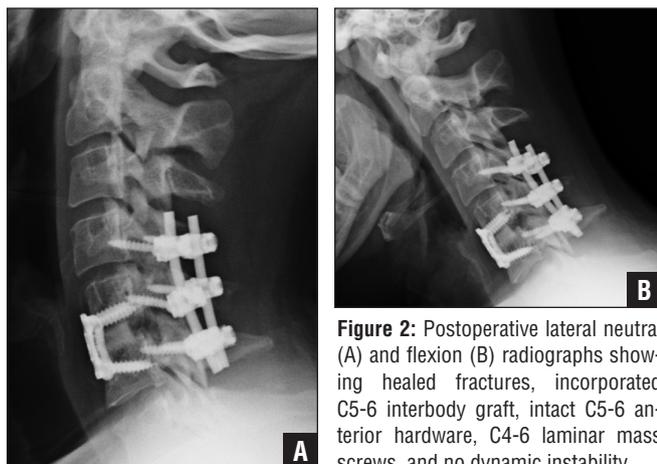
Postoperative lateral neutral (A) and flexion (B) radiographs showing healed fractures, incorporated C5-6 interbody graft, intact C5-6 anterior hardware, C4-6 laminar mass screws, and no dynamic instability.
